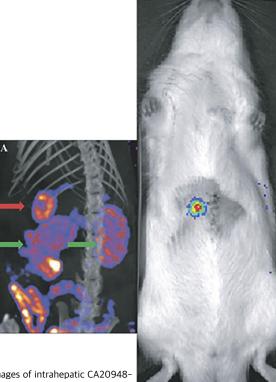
SPECT/CT (A) and bioluminescence (B) images of intrahepatic CA20948–luc tumor. Green arrows indicate the kidneys; the red arrow indicates the tumor.
